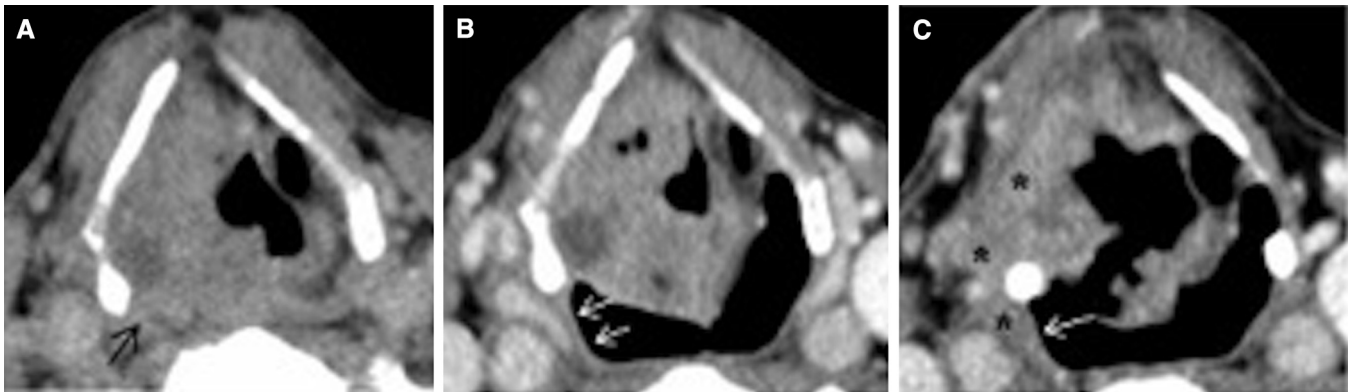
Contrast-enhanced axial plane computed tomography images of a 66-year-old man evaluated for laryngeal carcinoma. (A) There is suspicious invasion of the right pyriform sinus (black arrow) on images obtained during a routine scan. (B, C) Images obtained during “e” phonation clearly demonstrate submucosal involvement of the lateral sinus, as well as the posterior pharynx wall (asterisks in C), with extension through the thyrohyoid membrane. Note the intact mucosa (white arrows in B and C). There is loss of mucosal pliability with reduced distention of the right pyriform sinus.
